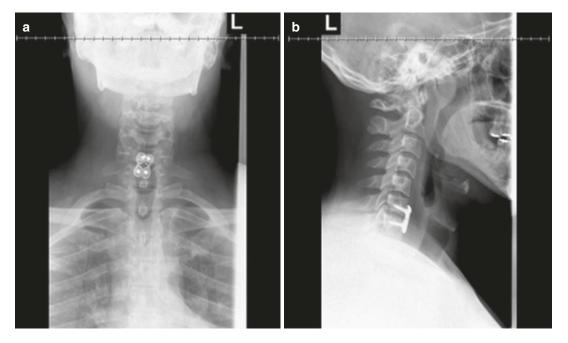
(a, b) Postoperative X-ray of a single-level anterior cervical discectomy and fusion
